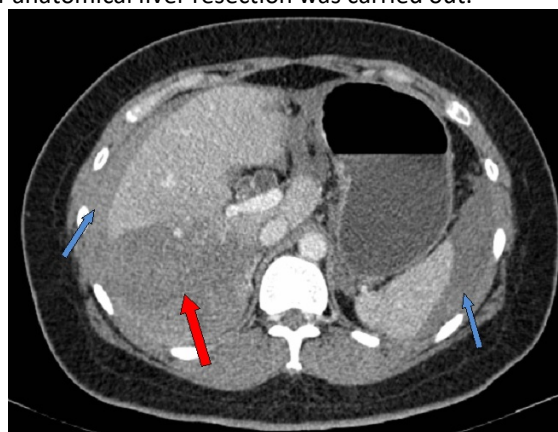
Contrast enhanced computed tomography of abdomen in Axial view showing devascularized liver segments of VI, VII and VIII (red arrow) with hemoperitoneum over perihepatic and perisplenic area (blue arrow).
